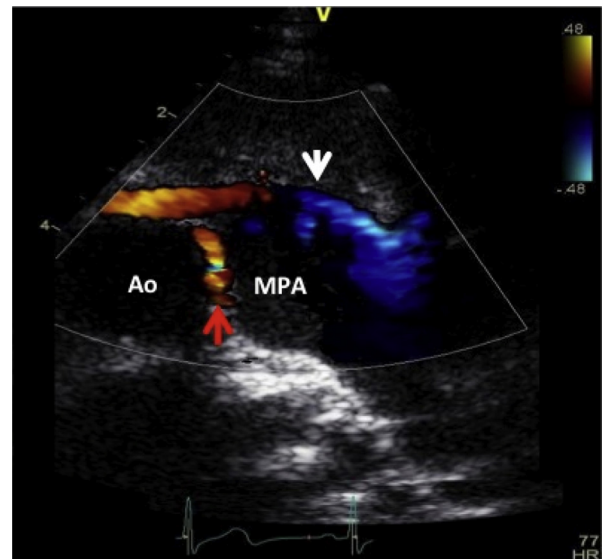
Modified parasternal short-axis view with color flow Doppler demonstrating the ARCAPA (*white arrow*) with diastolic retrograde flow into the main pulmonary artery (MPA) as well as the prominent collateral coronary vessel (*red arrow*). Ao, Aorta.
